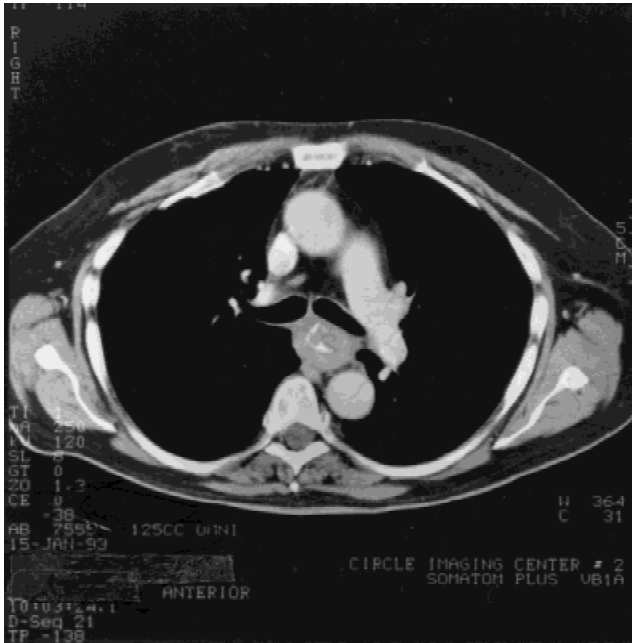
CT scan demonstrates mass in the esophagus at the level of and abutting the carina. There is no evidence of invasion into the tracheobronchial tree.
